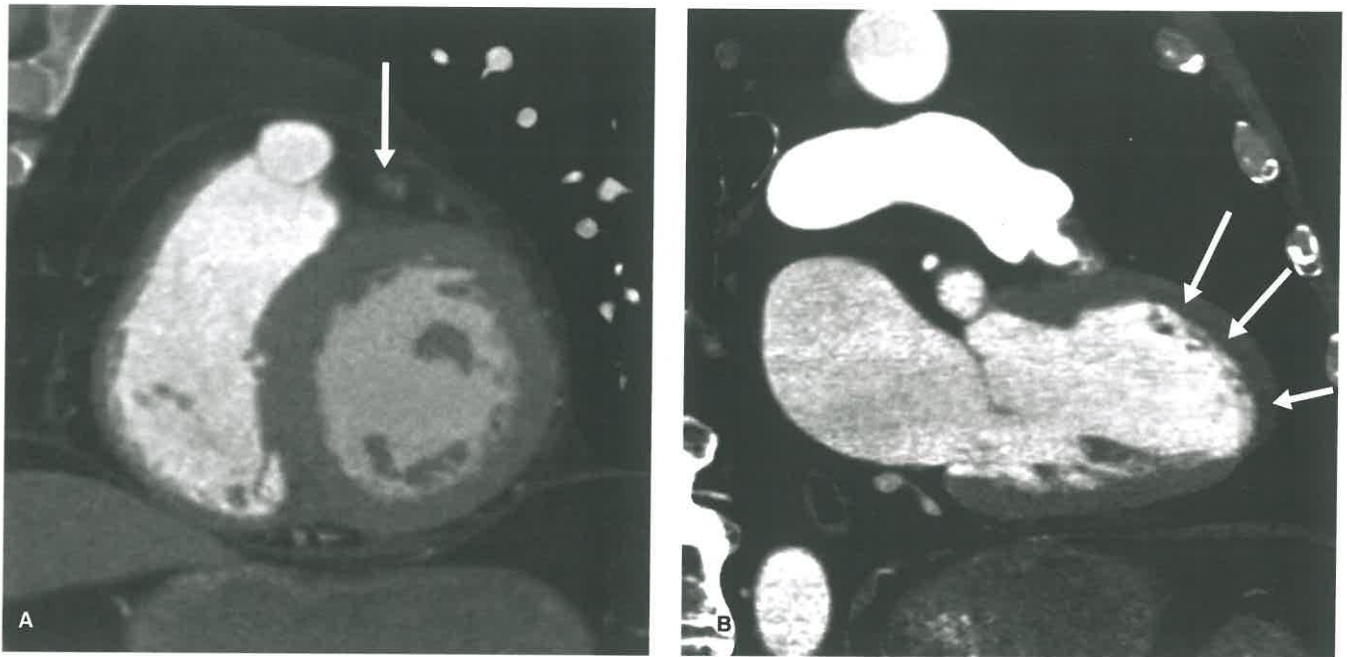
Subendocardial Hypoperfusion in a 60-Year-Old Woman With Chest Pain. A: Short-axis image through the mid-cavity of the left ventricle shows a severe stenosis of the LAD (*white arrow*). B: Two-chamber image demonstrates subendocardial hypoperfusion in the LAD distribution (*white arrows*). On CT, the hypoperfused myocardium could represent ischemic or infarcted tissue.
